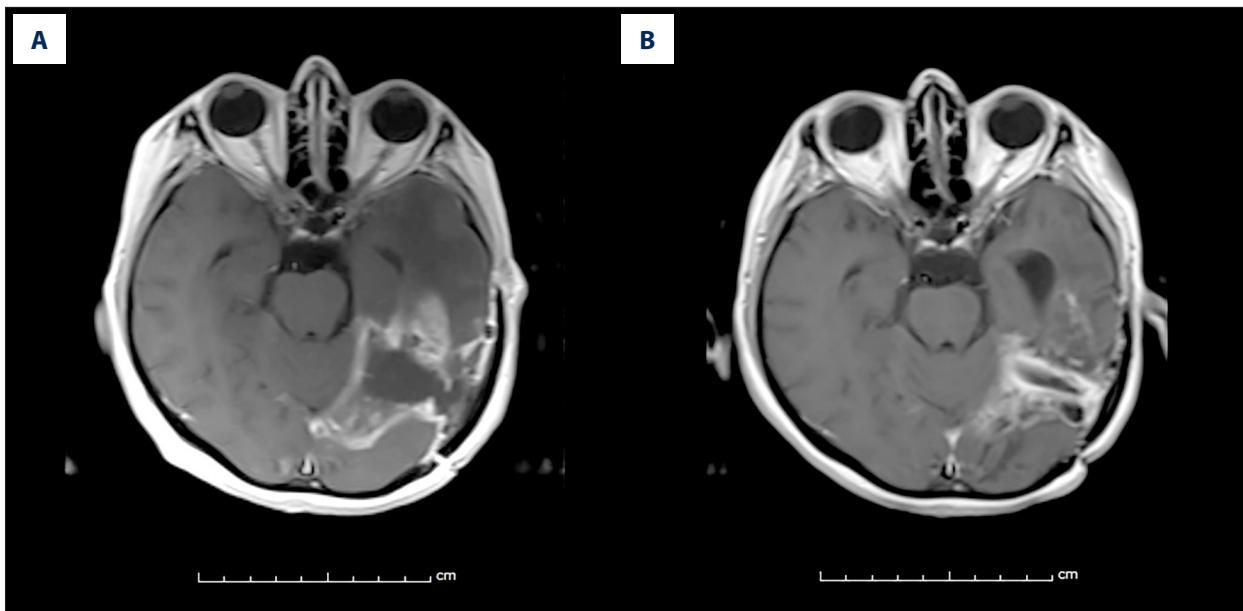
Axial contrast-enhanced T1-weighted MRI before and approximately 3 months after Gamma Knife treatment. (A) Baseline (pre-treatment) scan shows an irregularly enhancing temporal-lobe mass consistent with recurrent high-grade glioma. (B) Approximately 3-month post-treatment scan demonstrates decreased size and intensity of enhancement, compatible with radiographic response after dose-painted Gamma Knife stereotactic radiosurgery.
